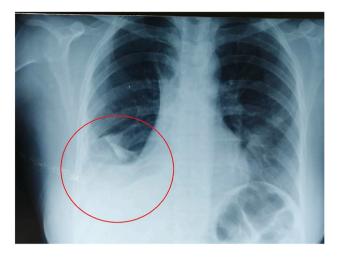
Chest x-ray was performed revealing heterogeneous opacity with illdefined borders.
